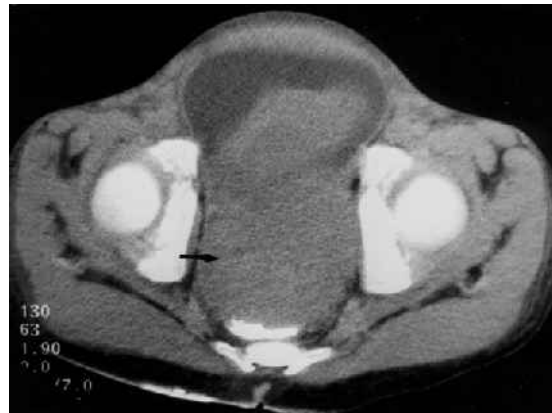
Contrast-enhanced CT image (with rectal contrast) of the pelvis shows a large soft tissue mass lesion (arrow) with invasion of the anterior rectal wall.
